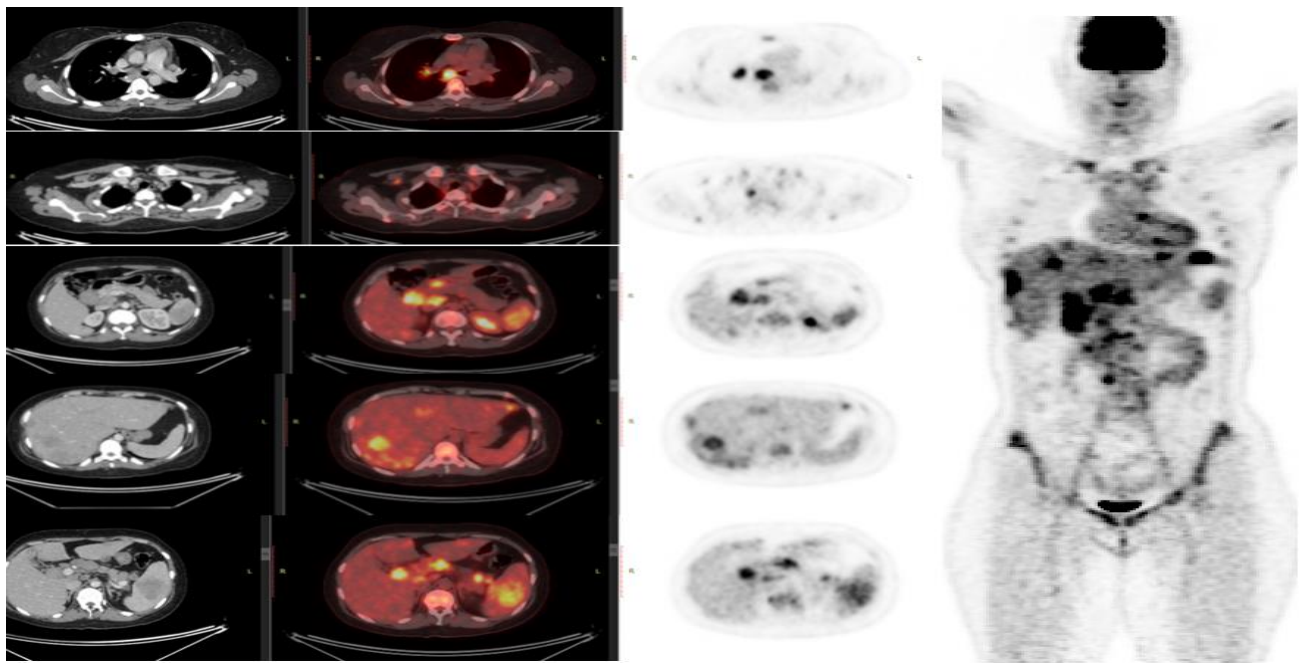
Whole body 18 F - FDG PET/CT
